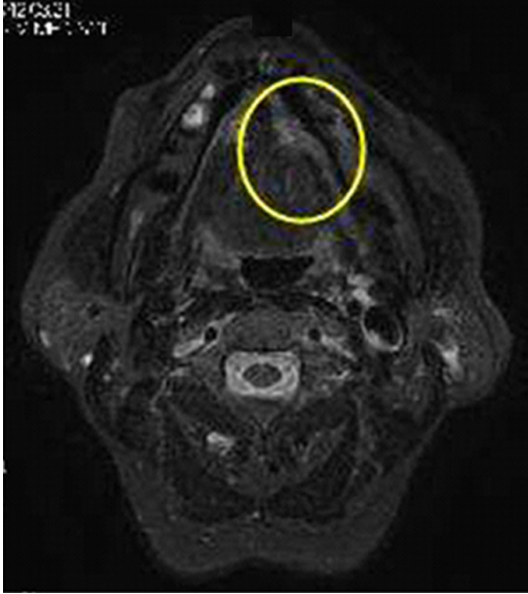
Magnetic resonance imaging showing a tumor in the left side of the tongue (within the circle).
